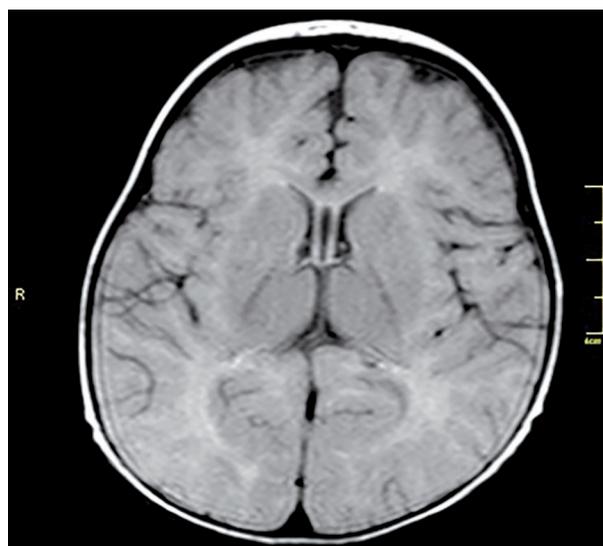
Brain MRI images showing increase in cerebral-cerebellar brain parenchyma and T1-T2 relaxation time and in the signal in corpus callosum (delayed myelination)
